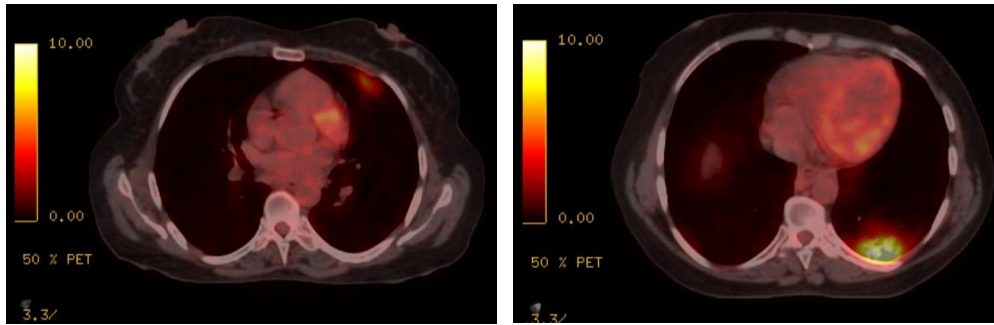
PET/CT images compatible with the patient's Covid pneumonia
